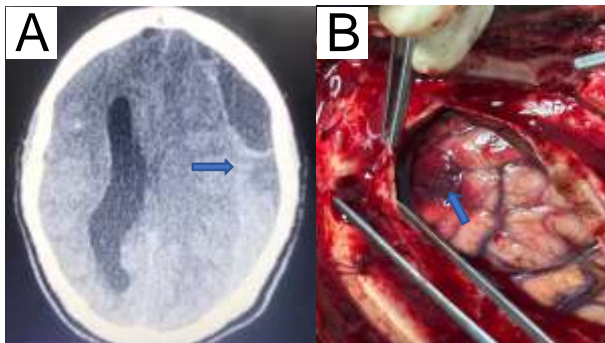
A) Non contrasted CT brain with left heterogeneous laminar multiloculated subdural collection. B) Intraoperative image with arrow showing small cortical arteriovenous malformation as likely cause of the evacuated spontaneous subdural hematoma.
